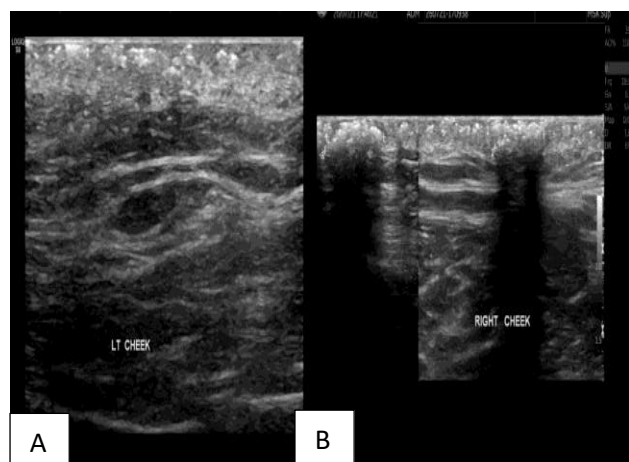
(A and B): Ultrasound of the left and right cheek showing multiple echogenic spots with posterior acoustic shadowing in the subcutaneous tissue.
